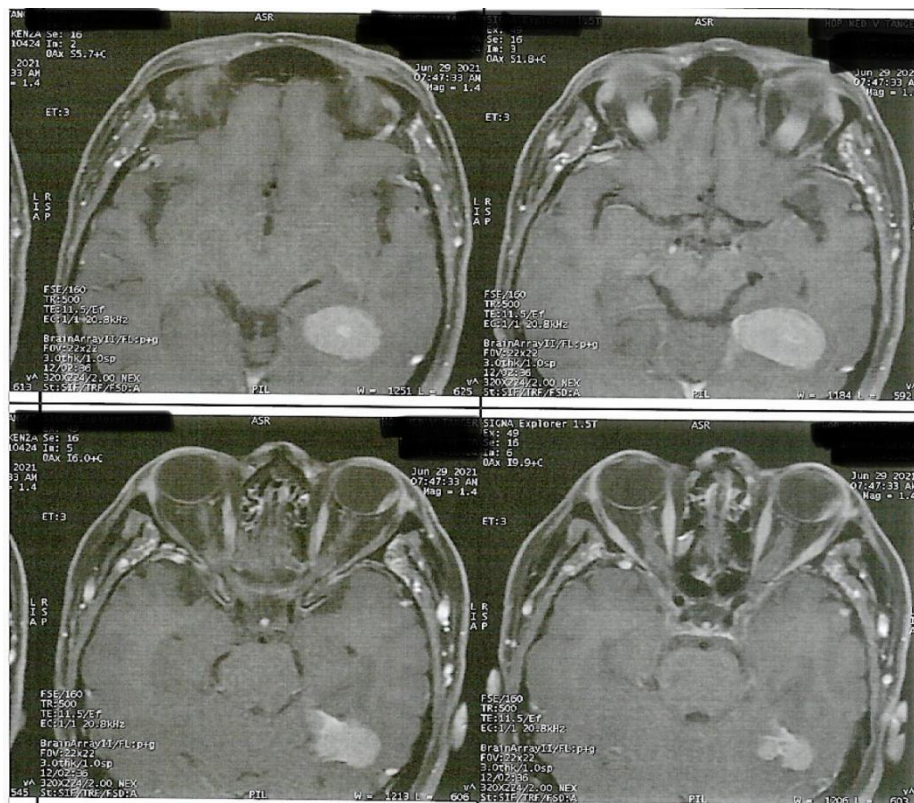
Brain MRI showing a left temporal occipital meningioma hyperintense on T2
